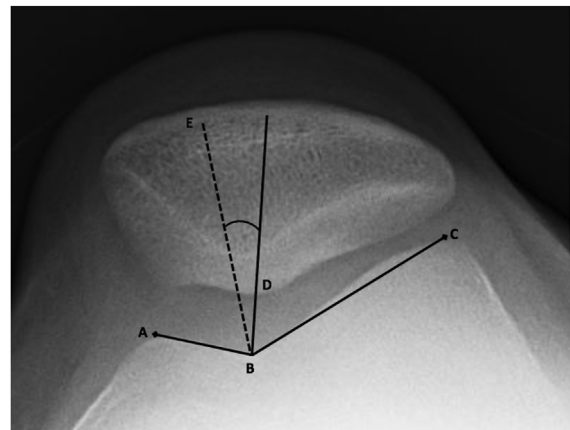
Axial radiograph depicting the congruence angle is between points D, B, and E. A and C are the highest points of femoral condyle. D is the lowest point of articular ridge of the patella. Line BE is the bisector of the angle between points A, B, and C.
